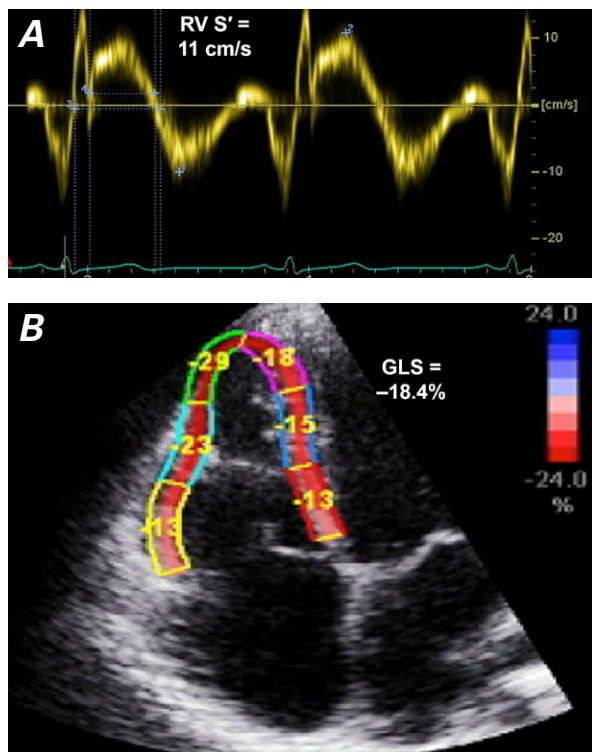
A) Tissue-Doppler echocardiogram (4-chamber view) shows systolic velocity (S') at the basal right ventricular (RV) free wall. B) Speckle-tracking echocardiogram (4-chamber view) shows RV global longitudinal strain (GLS).
